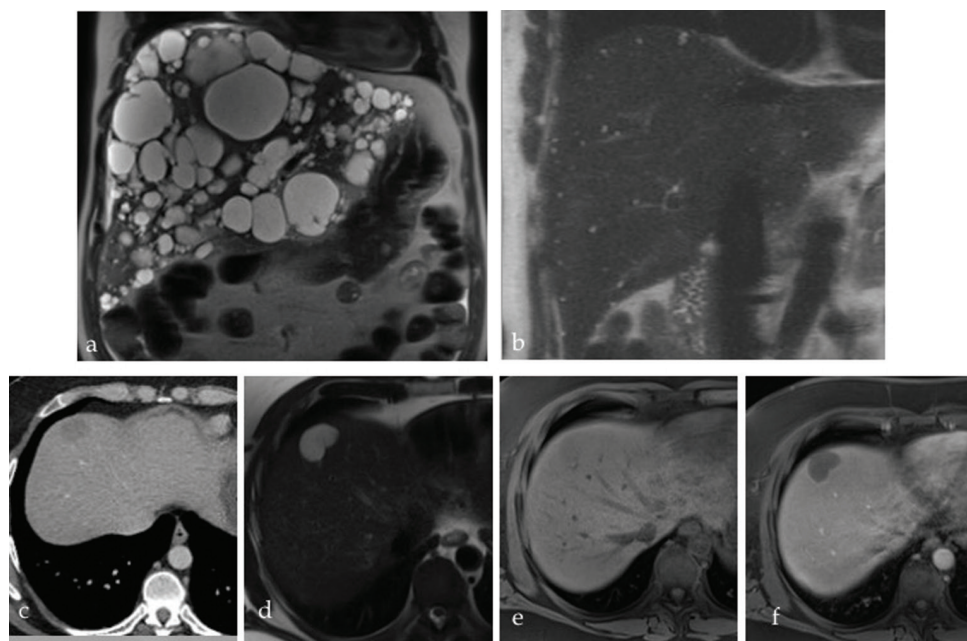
a. T2W magnetic resonance imaging shows polycystic liver disease with innumerable cysts replacing the liver. B. T2W magnetic resonance imaging of biliary hamartomas with numerous tiny cyst-like lesions. c. Computed tomography, (d) T2W magnetic resonance imaging, (e) T1W pre- and (f) post-contrast magnetic resonance imaging of ciliated hepatic foregut cyst, seen as a well-defined hypodense lesion on computed tomography, T2 bright and isointense on T1W without enhancement.
